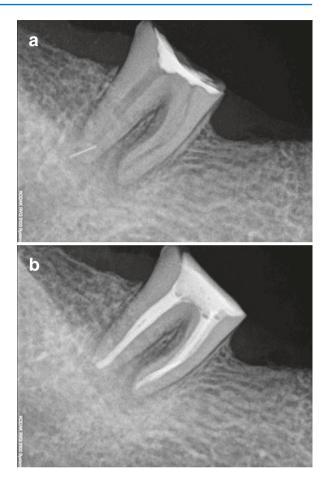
(a) Preoperative radiograph of a mandibular molar with a fragment in the distal root protruding to the periapical tissues. (b) Removal of the loose fragment attached to the softened gutta-percha. (c) Immediate post-obturation radiograph (Courtesy of Dr. K. Mastoras)
